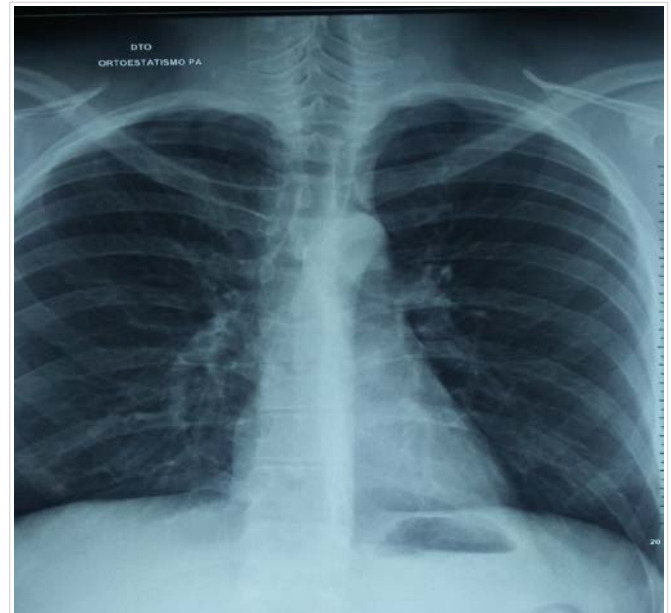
Plain chest X-ray, posteroanterior view.
